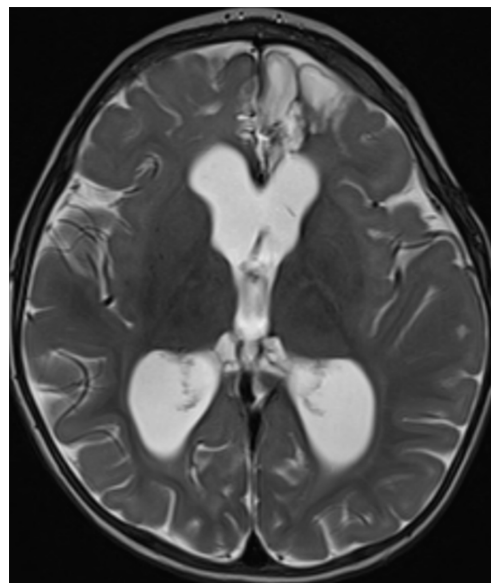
Magnetic resonance imaging T2 axial image showing encephalomalacia in the medial left frontal lobe with mild ventriculomegaly. The external ventricular drain was removed, and a permanent cerebrospinal fluid diversion was placed with a ventriculoperitoneal shunt.
